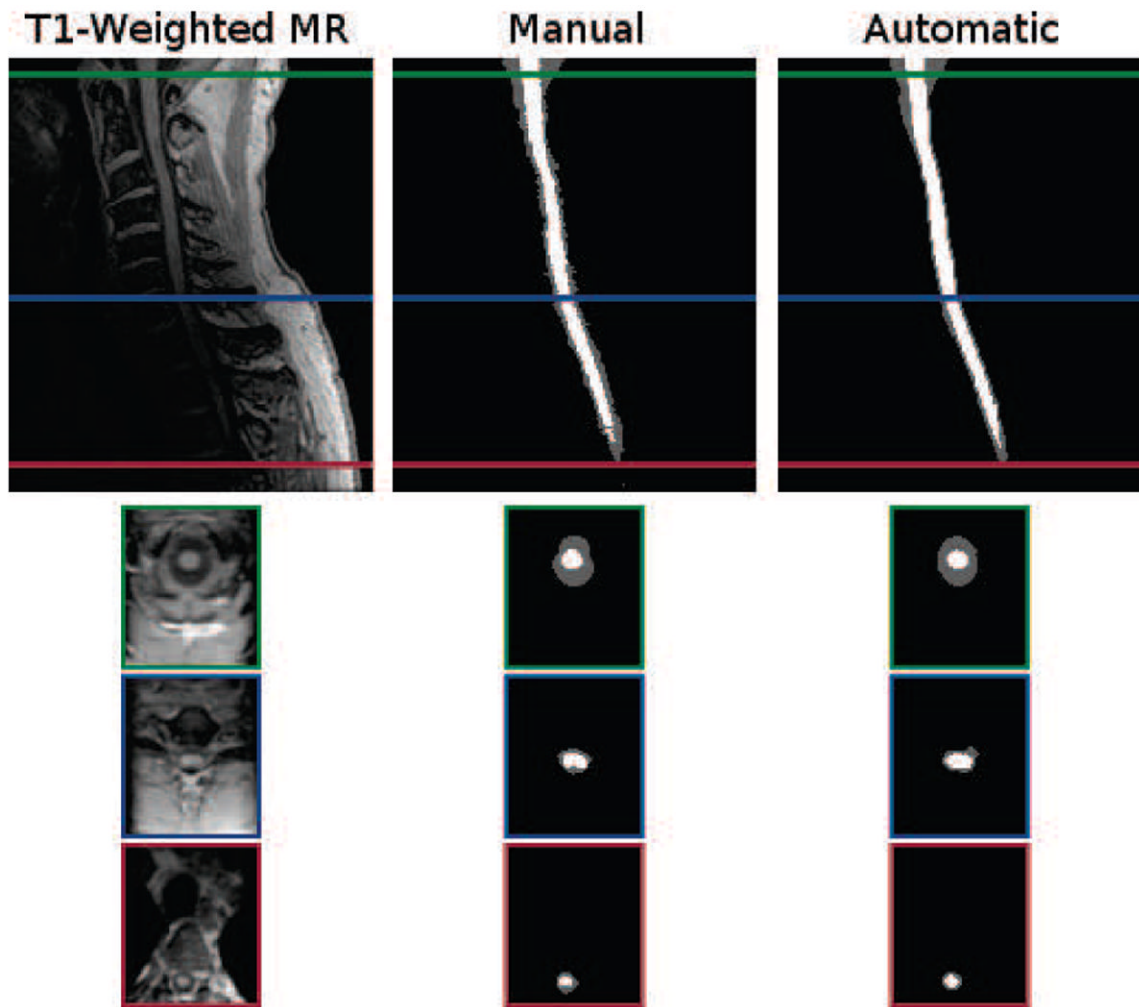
Cropped example of a T1-weighted MRI segmentation by a human rater in comparison to the result from our algorithm. Shown are one sagittal and three axial views. The colored border around the axial slices denote the respective cross-section within the sagittal image. The Dice coefficient between the shown manual and automatic segmentations are 0.87 for the spinal cord (white) and 0.73 for the CSF (gray).
